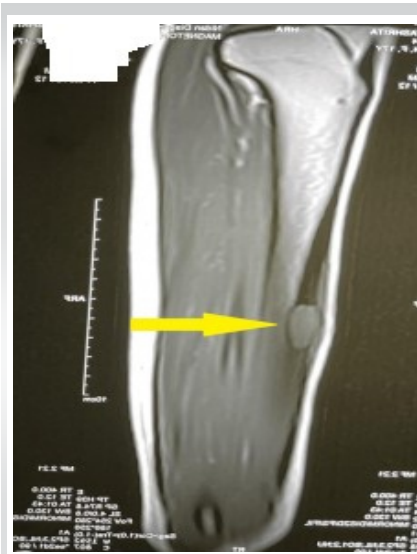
Pre-operative magnetic resonance imaging (sagittal section). Yellow arrow pointing to a well-circumscribed cystic lesion.
